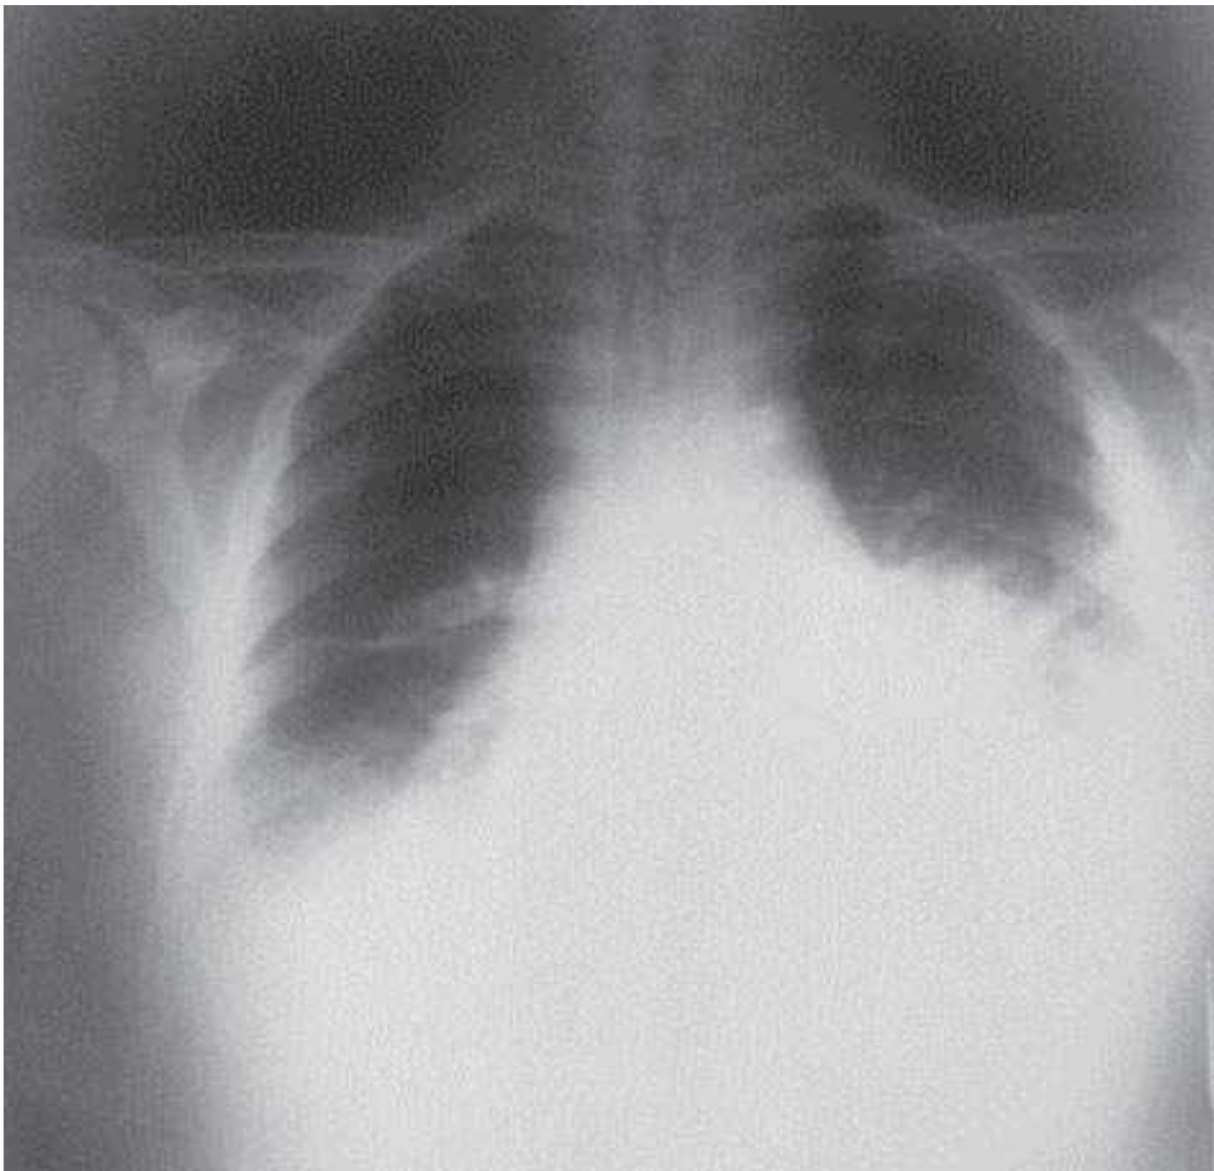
Chest radiograph from a patient with anthrax showing mediastinal widening and a pleural effusion. [From the CDC Web site: <http://www.bt.cdc.gov/agent/anthrax/anthrax-images/inhalational.asp>.]
